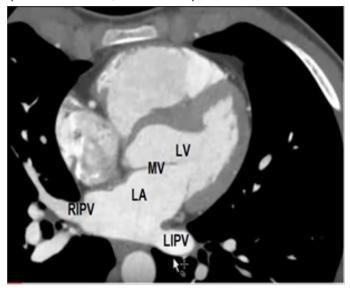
Computed tomography of the heart. The image shows both inferior pulmonary veins that can be found in the same plan with the mitral valve.
